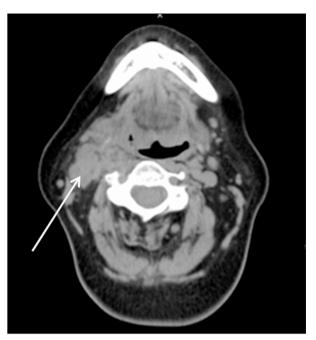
CT scan with enlarged level II lymph nodes in the right neck (arrow).
